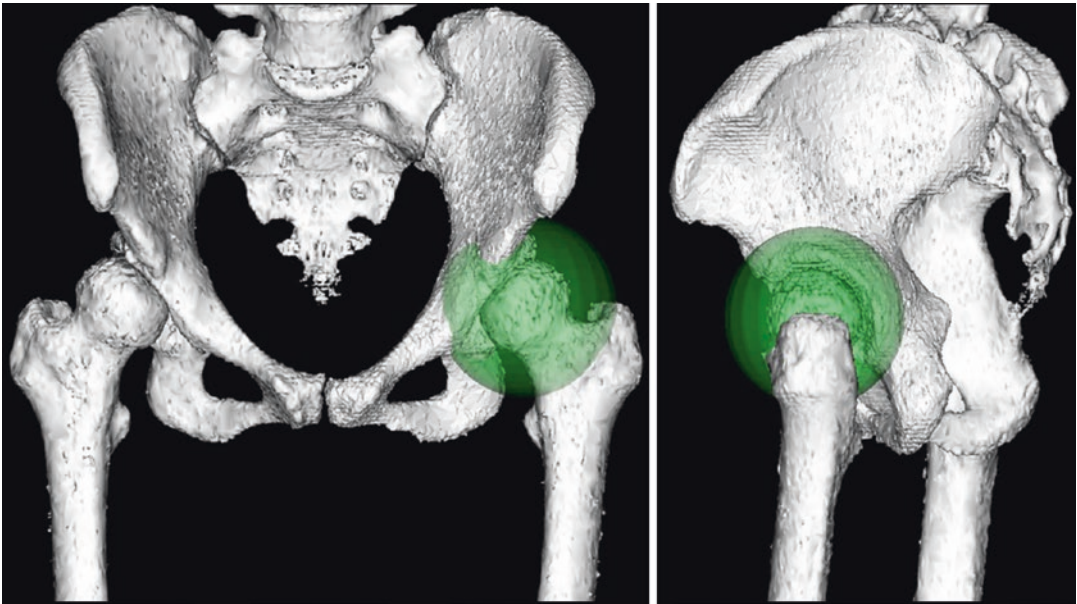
CT-based preoperative planning. An osteotomy sphere with a minimum 15 mm thickness of acetabular fragment is shown (green)
